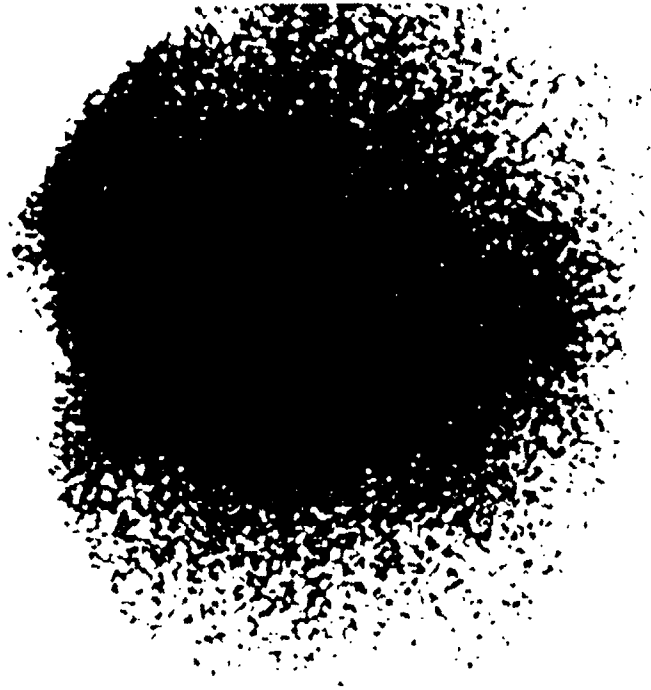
MRI and scintigram of a patient with cystic astrocytoma before and after ^{166}Ho -chitosan therapy. MRI before therapy(left), scintigram after injection of ^{166}Ho -chitosan(middle), MRI three months after therapy(right).
